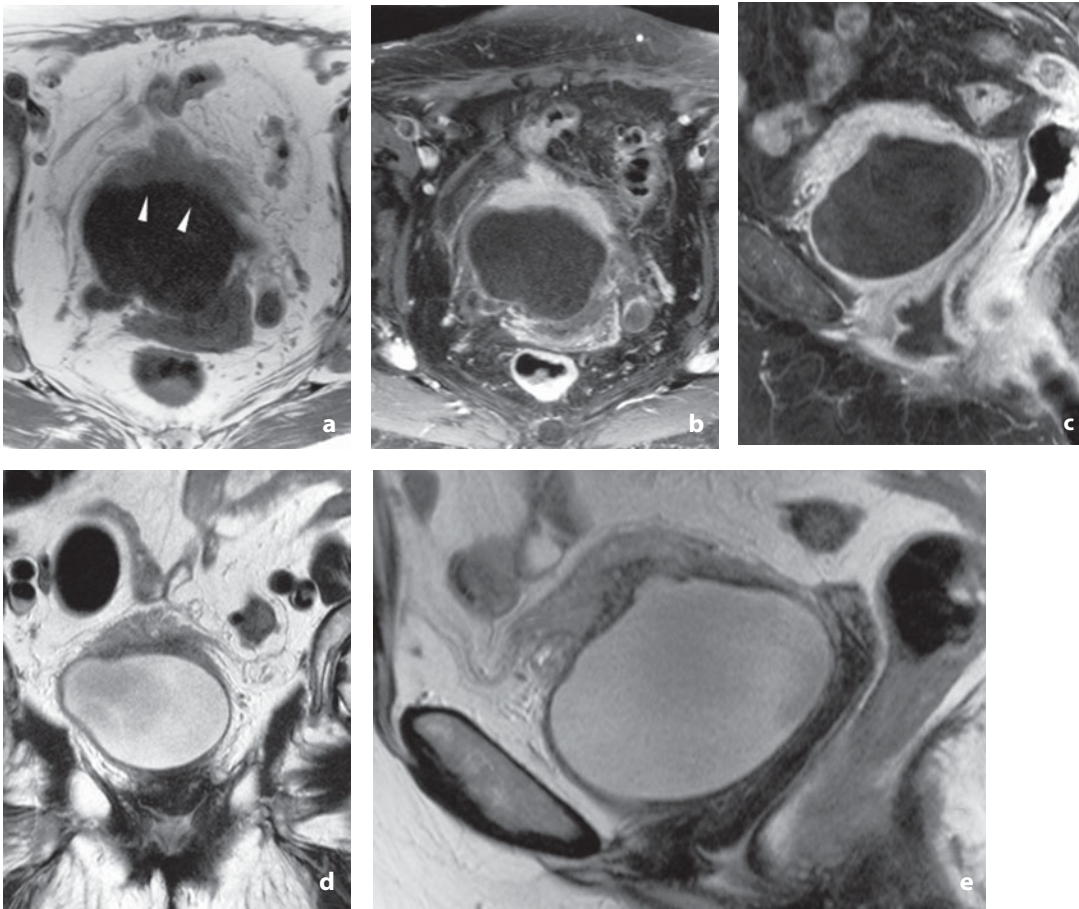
Magnetic resonance. Bladder pseudotumor. a Baseline T1-weighted image shows nonuniform plaque-like thickening at the bladder dome (*arrowheads*). b After contrast medium injection with fat saturation, marked enhancement of the lesion is appreciable, evident also in the contrast-enhanced sagittal T1-weighted sequence (c) and the coronal and sagittal T2-weighted images (d,e). Differential diagnosis with an invasive bladder cancer is challenging
